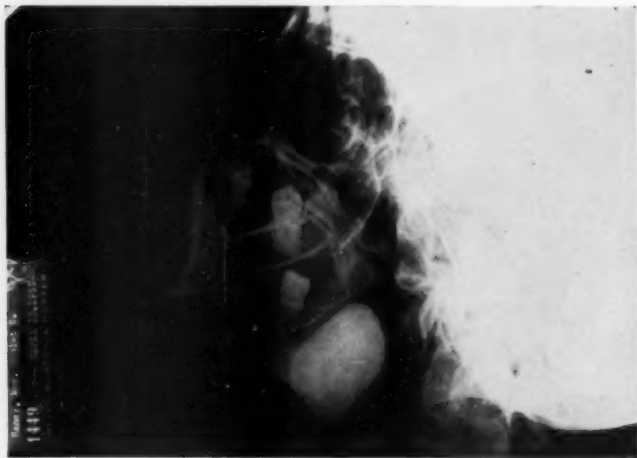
Case 1. Osteoma of Mandible as seen by X-ray.
